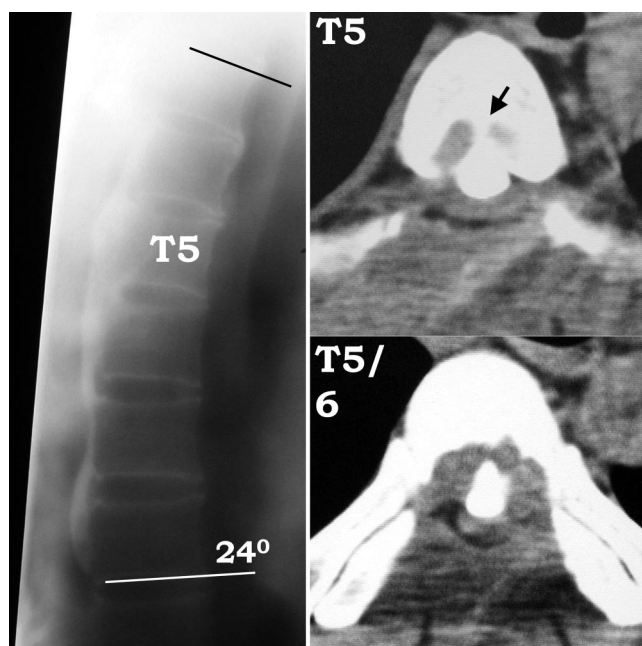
Radiographic images obtained 3 weeks after the first surgery. A midsagittal tomogram (left) shows increased thoracic kyphosis at T3–T8, measuring 24°. Axial CT images at T5 (right, upper) and T5–T6 (right, lower) indicate that the extirpation of OPLL is completed at T5–T6 but incomplete at T5 (arrow).
